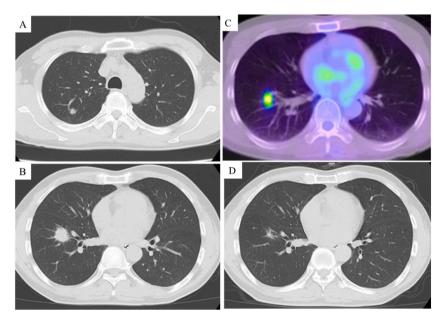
Computed tomography of the chest showing a 7-mm nodule shadow in the right upper lobe (A) and a 20-mm nodule shadow in the right lower lobe (B). PET-CT showing SUV-max 4.11 matching with a right lower lobe nodule shadow (C). Computed tomography of the chest showing resolution of the nodules at 3 months after admission (D).
